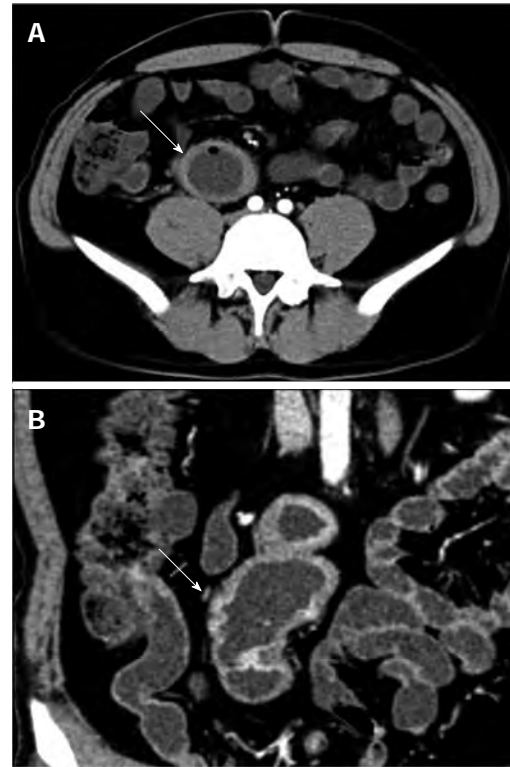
Computed tomography enterography scan. A: Transverse view showed suspicious ileal intussusception (white arrow) in the right lower quadrant; B: Coronal view revealed a similar result (white arrow).
